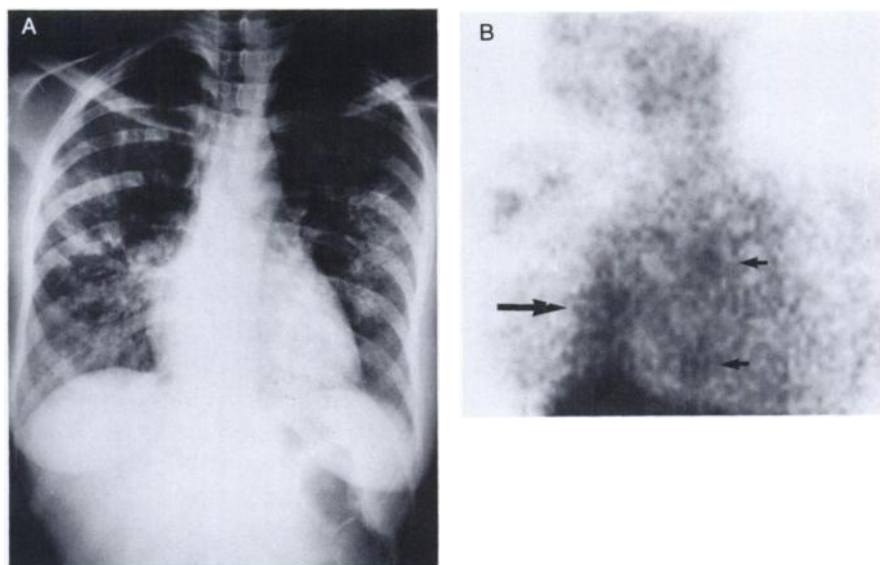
Diagnostic studies of an HIV-infected patient (no. 1392) presenting with confirmed PCP. (A) PA chest roentgenogram showing bilateral diffuse patchy interstitial and alveolar infiltrates. (B) Twenty-four hour anterior chest antibody scan shows diffuse uptake in right lower lobe with possible extension into the middle lobe (large arrow) and two areas of focal uptake in the left lung (small arrows).
